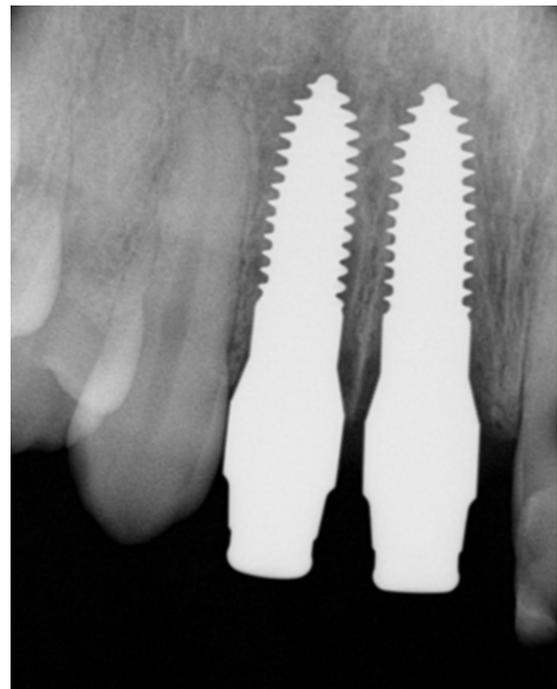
Implants #7 #8 postoperative x-ray.
